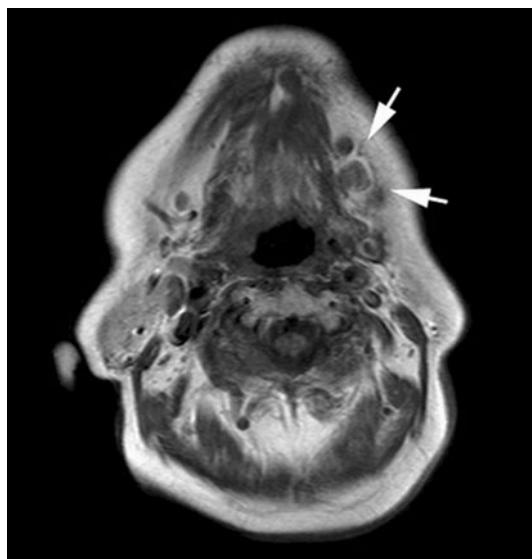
MR image. Suggesting left submandibular lymph node metastasis
